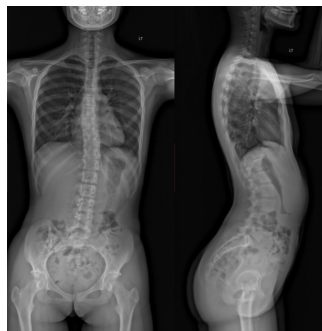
Radiologic assessment of patients with AIS: coronal and sagittal full-spine radiographs.
